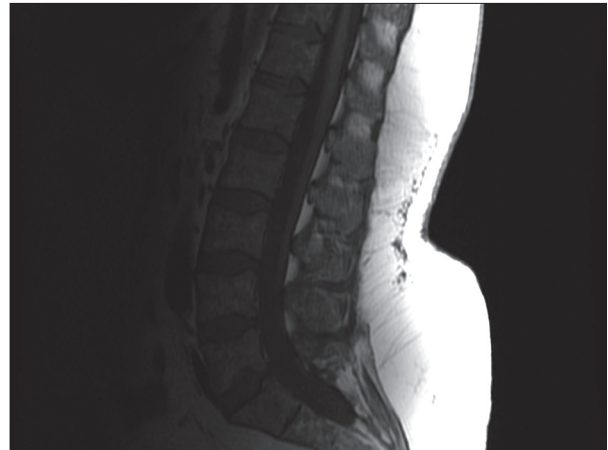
T1-weighted magnetic resonance scan obtained in sagittal plane in patient diagnosed with the RAEB subtype of myelodysplastic syndrome.
